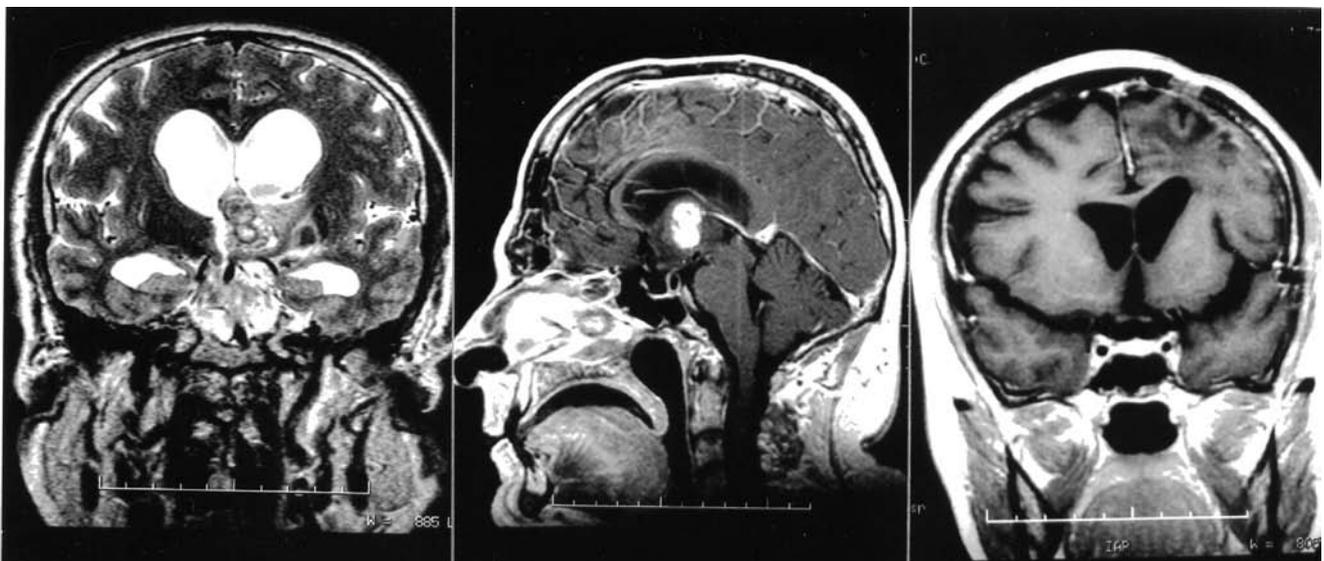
Left: Preoperative MRI, T2-weighted coronal image showing an heterogeneous lesion that presents areas of previous hemorrhage and associates edema spreading through the left basal ganglia. Middle. Preoperative MRI, T1-weighted sagittal image after gadolinium injection showing an oval shaped lesion in the area of the third ventricle and hypothalamic area that enhances heterogeneously. Right: Postoperative MRI control shows absence of both tumor and perifocal edema.*
